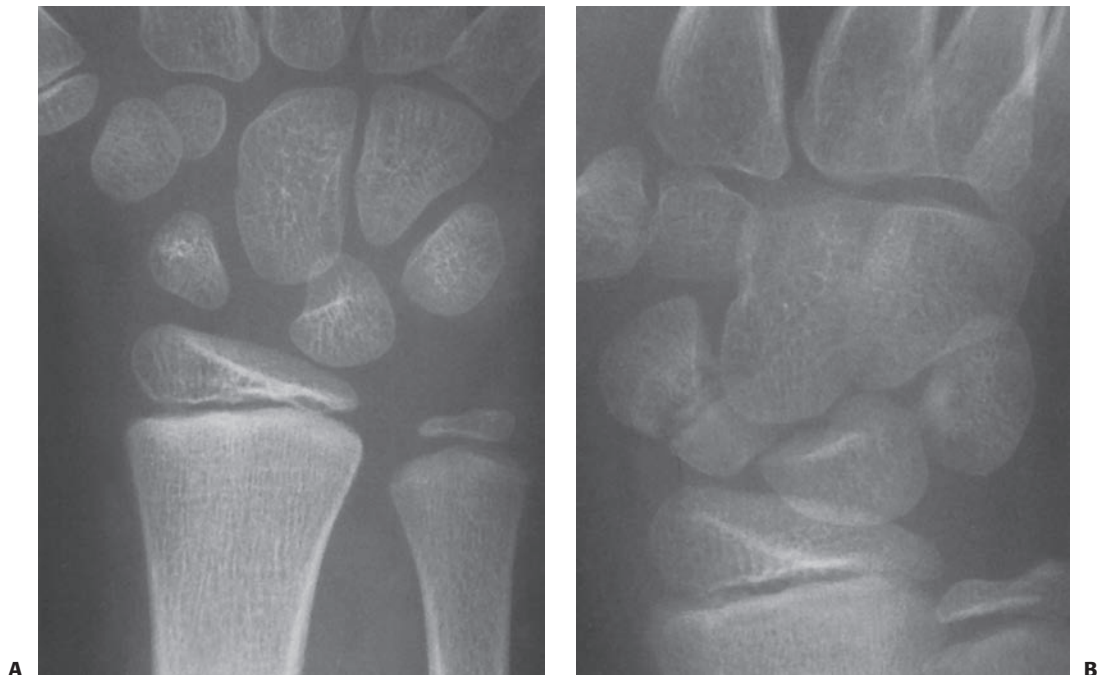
A: A 9-year-old boy who fell on an outstretched wrist and had radial-sided pain and tenderness; original radiographs failed to reveal any bony abnormalities. B: About 1.5 years later, he had persistent radial-sided wrist pain, and radiographs revealed a midwaist scaphoid nonunion. This would *not* be considered a bipartite scaphoid but instead an injury that was sustained when the cartilaginous anlage was present. (continues)
